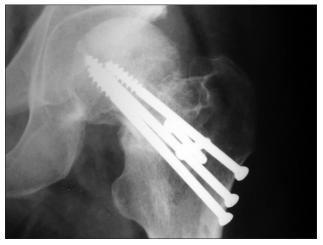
X-ray left hip joint anteroposterior view showing avascular necrosis changes in femoral head
